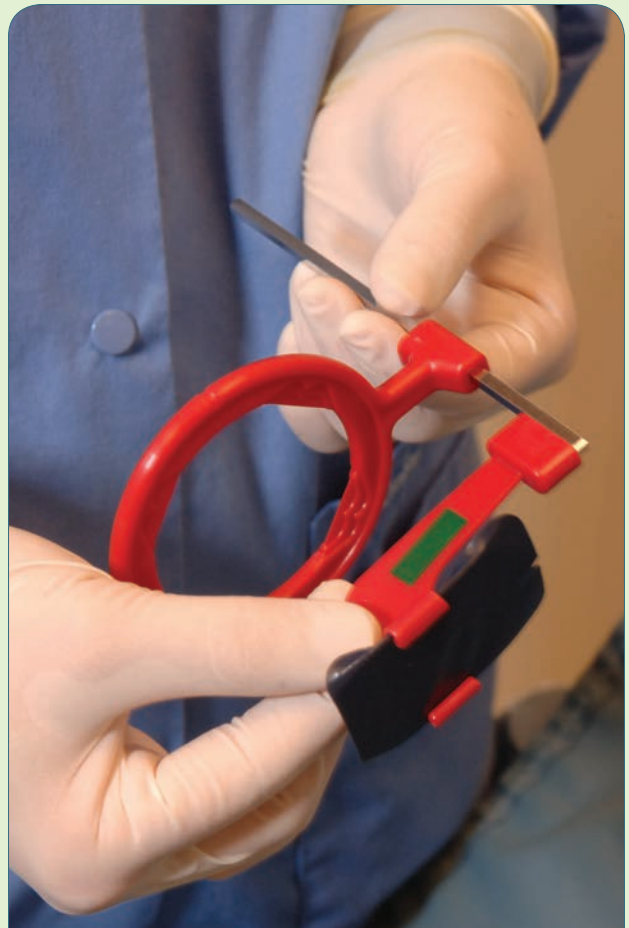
Sensor being placed in the Rinn x-ray film holder.
